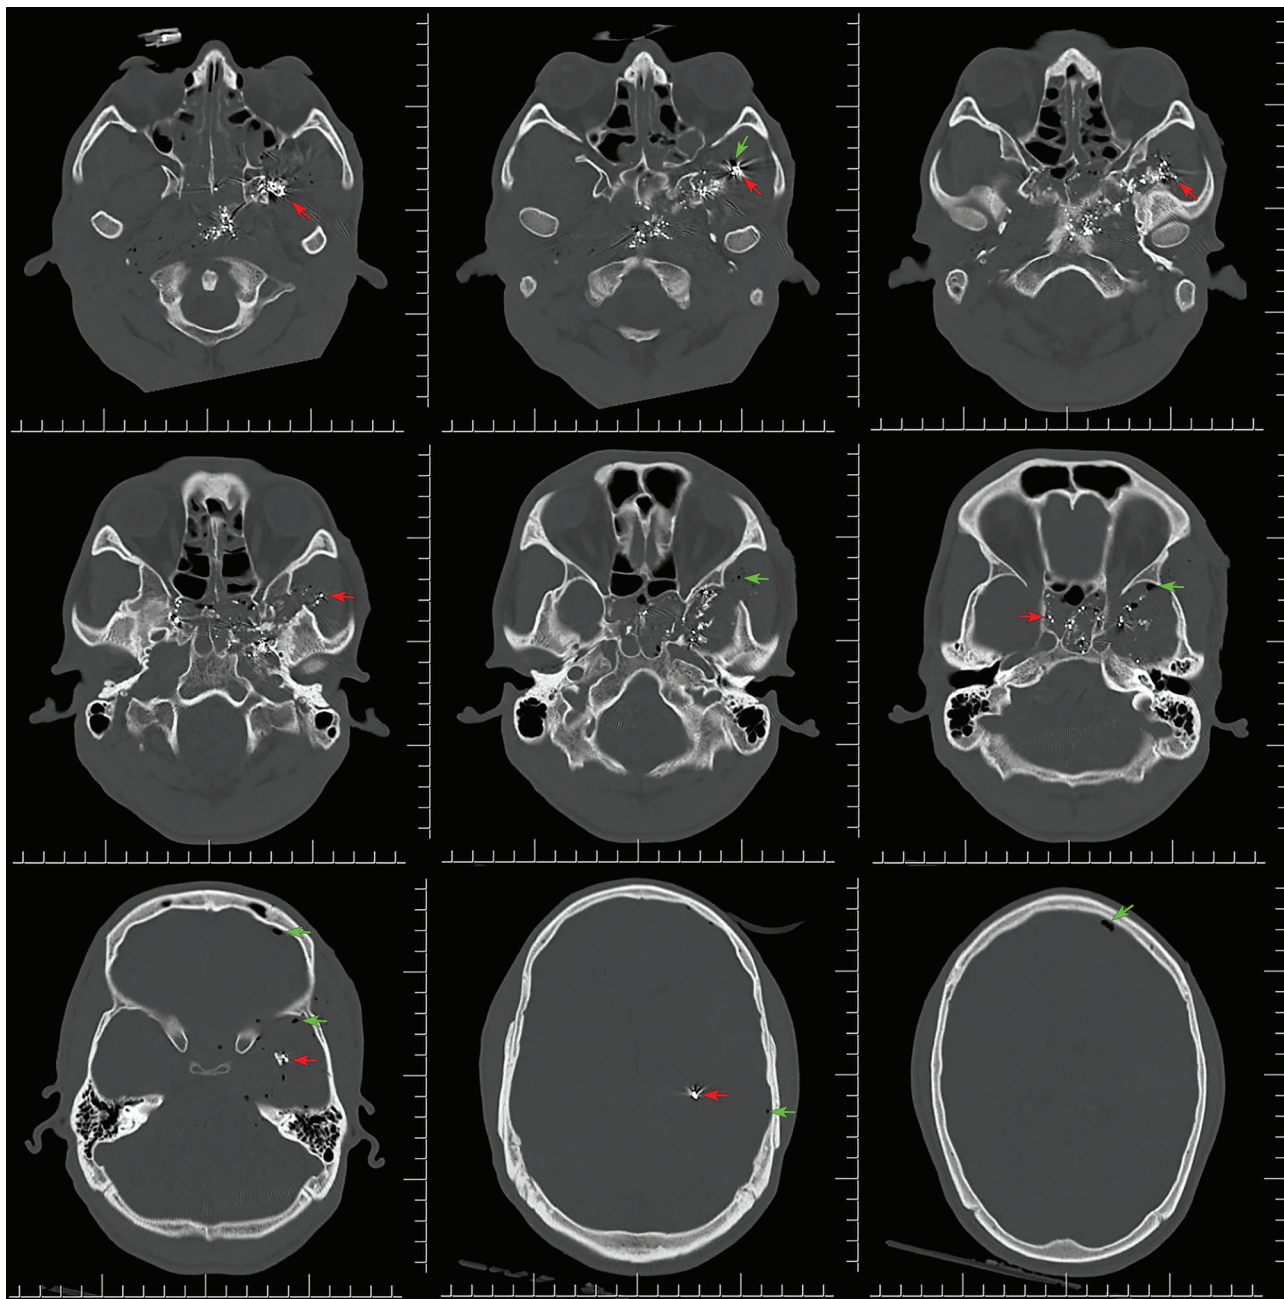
Axial slices of head CT without contrast in the bone window show air in the subdural space (green arrows), multiple metallic elements (2980 HU) no larger than 3 mm at the base of the skull and left temporal and parietal lobe (red arrows), loss of continuity of the greater wing of the left sphenoid with hypertensive liquid content in the sphenoidal sinus, and loss of continuity of the left lateral wall of the sphenoid sinus and of the lateral wall of the left maxillary sinus.
